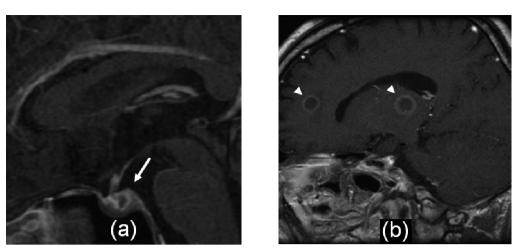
MRI of the brain (sagittal view) shows: (a) A peripherally enhanced lesion (arrow) in the posterior lobe of the pituitary gland on a post-Gd T1-weighted image (T1WI). (b) Several lesions (arrow heads) with rim-enhancement are seen on a post-Gd T1WI, located at the right thalamus and the right frontal lobe. These findings are consistent with the presence of metastases.
